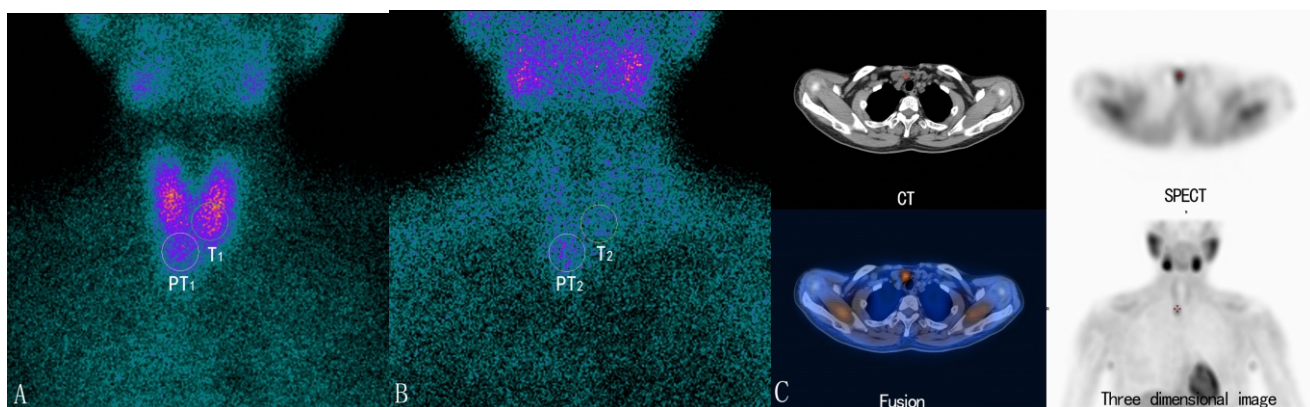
A 45-year-old woman with aPHPT in which a parathyroid adenoma has been confirmed. Regions of interest of equal pixel numbers were drawn around the abnormal parathyroid and the contralateral normal thyroid. Parathyroid scintigraphy (A: early-phase ^{99m}Tc -MIBI planar scintigraphy. B: delayed-phase ^{99m}Tc -MIBI planar scintigraphy. C: ^{99m}Tc -MIBI SPECT/CT) showed a mildly increased focal uptake below the right lower pole of the thyroid and a nodule in corresponding area on SPECT/CT (red cross).
